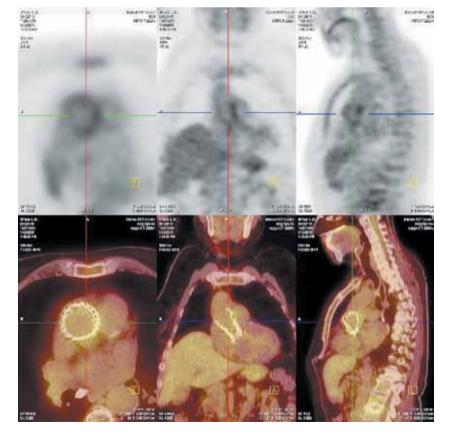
18F-FDG PET-CT imaging, pathological hypermetabolism in the bioprosthetic aortic valve projection
